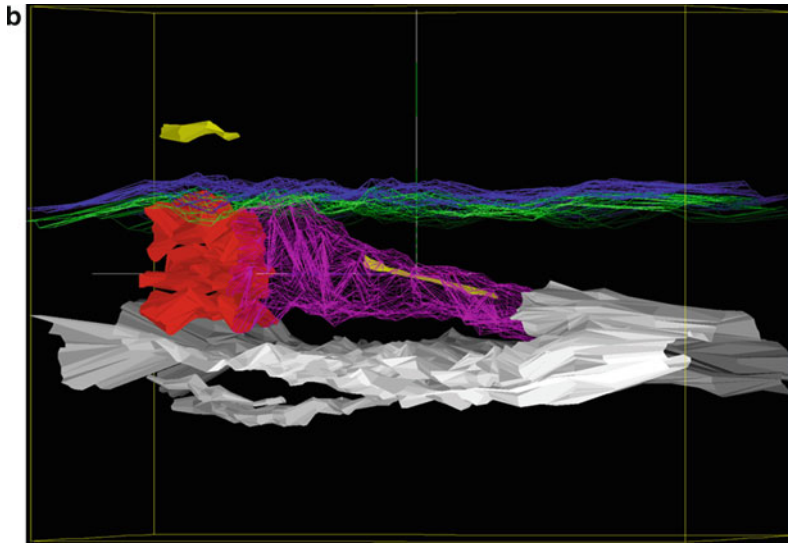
Serial sections (a) and three-dimensional reconstruction of the hair follicle complex on the calf of a 23-year-old woman at 50 MHz. Voxel cube of 3,2 mm (thickness) \times 6 \times 6 mm. Sections were taken at 50 μ m intervals. (a) The sonograms of the left column are perpendicular to the sonograms of the right. *Left upper* sonogram: sharply delimited trifoliate echopoor structure at the dermis-subcutis interface. *Left middle* sonogram: hair follicle canal. *Left lower* sonogram: ill-defined lobular structure of the sebaceous gland. *Right* sonograms: longitudinal
